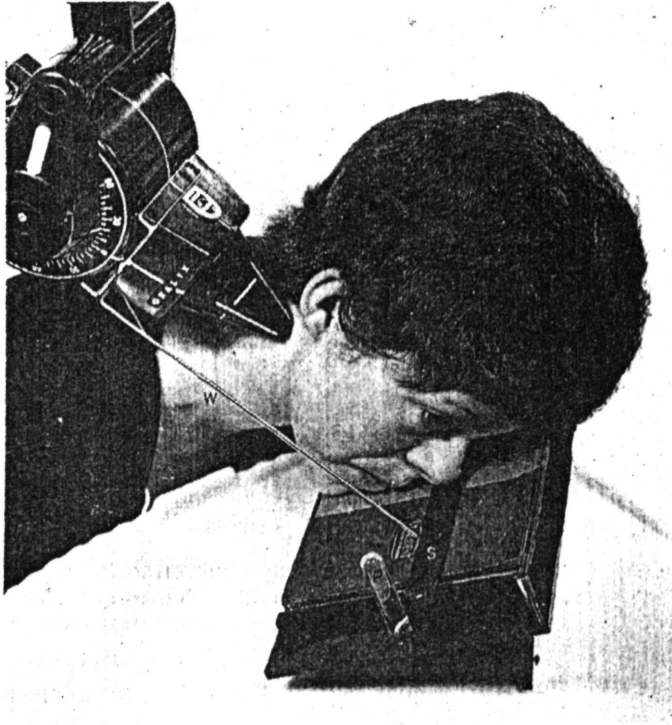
Relationship of the tube, patient and the cassette when taking a rotated oblique lateral radiograph. W is the wire antenna, P the ear post, F the lead rubber flap and S the strip over the lead markers.
